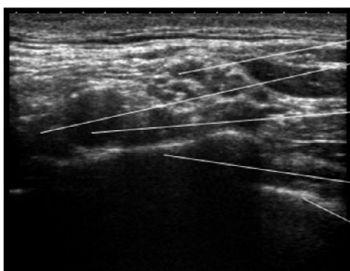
Ultrasound anatomy of interscalene nerve block. CA, Carotid Artery; IJ, Internal Jugular Vein; SCM, Sternocleidomastoid; AS, Anterior Scalene; MS, Middle Scalene; BP, Brachial Plexus
